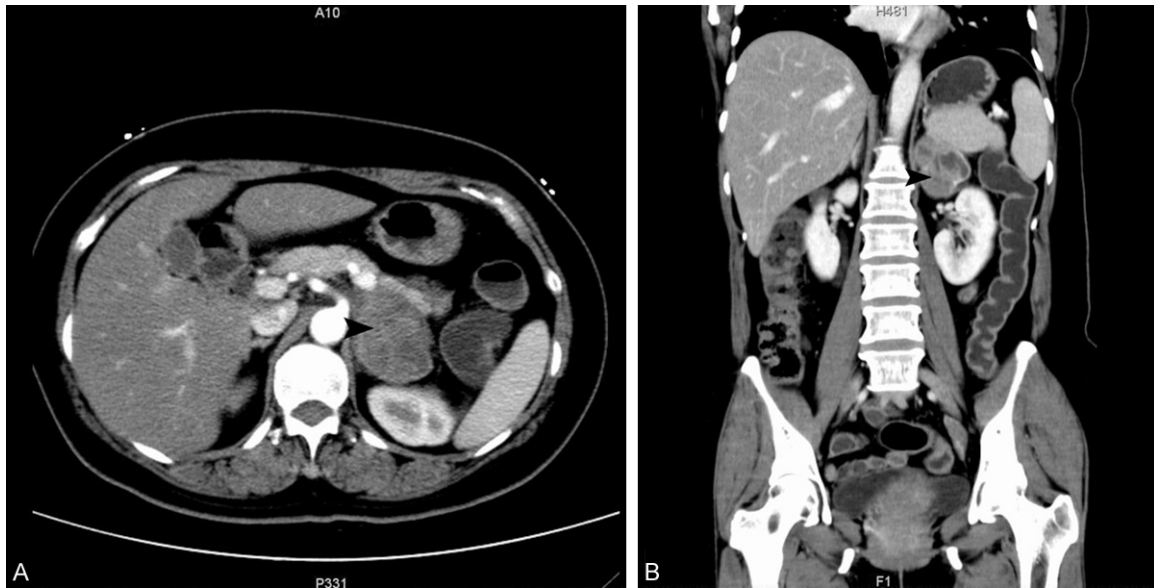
Computed tomography showed a well-circumscribed heterogeneously mass in the left suprarenal areal (arrowhead). (A) Axial sections and (B) coronal sections.
